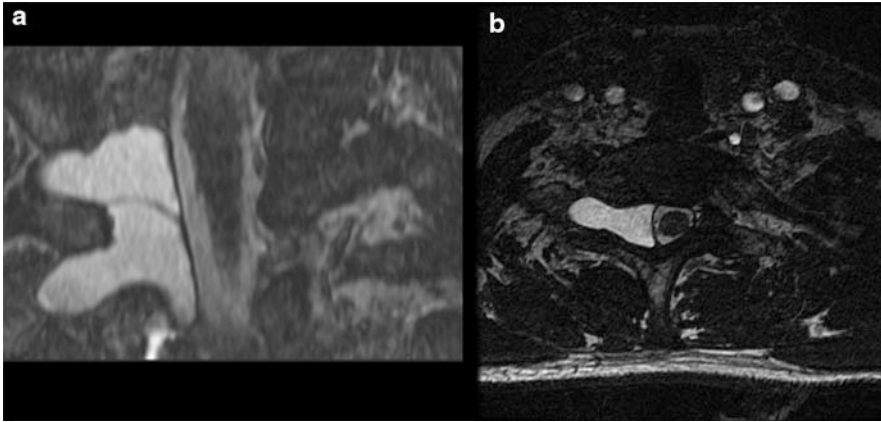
CT myelogram of patient with root avulsion on right at C6 and C7 levels. (a) Large pseudomeningocele extending into the right neural foramen at C7-T1 level on
